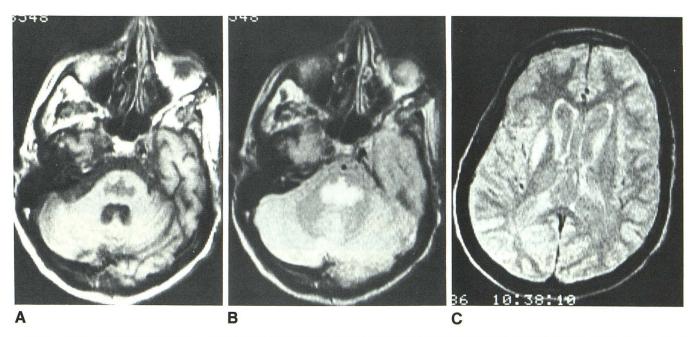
A, T1-weighted MR image at same level as Fig. 1. Trident-shaped hypointense area in pons. Ventrolateral sparing is in location of corticospinal and corticobulbar tracts.
